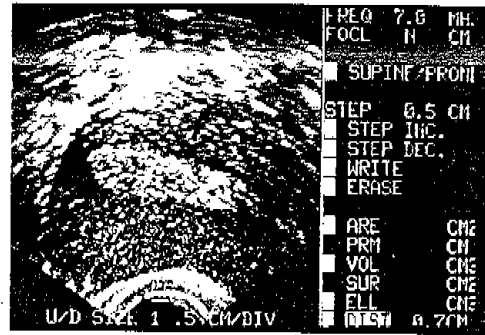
Sonogram showing hyper-echogenic pattern.
